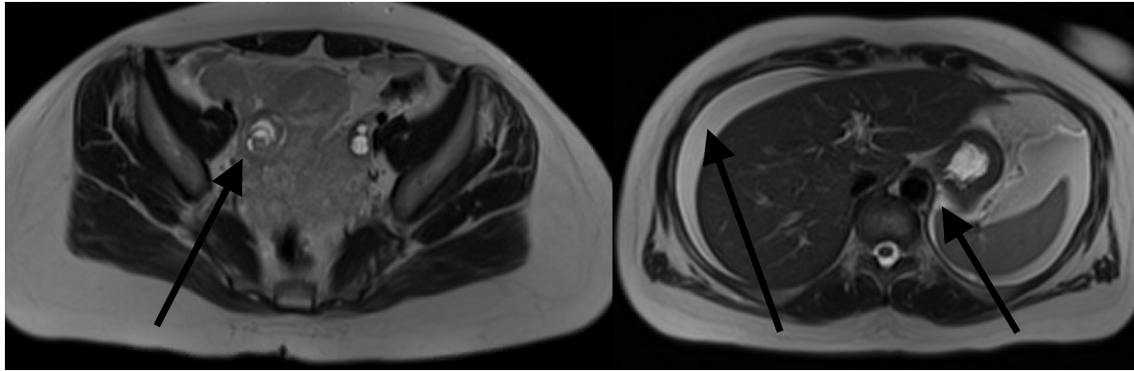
Magnetic resonance imaging demonstrating a complex fluid collection around the liver and spleen. The arrow on the left indicates the site of the likely hemorrhagic cyst. The first arrow on the left points to free fluid around the liver with the second pointing to free fluid around the patient's kidney and spleen.
